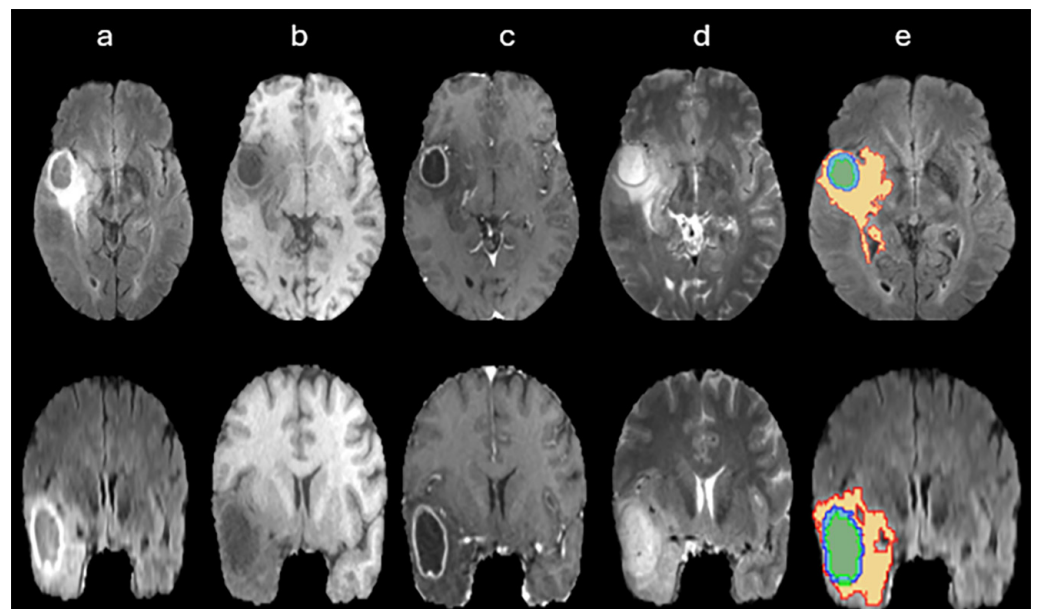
Brain tumor examples from the BraTS 2020 training dataset of different MRI sequences
